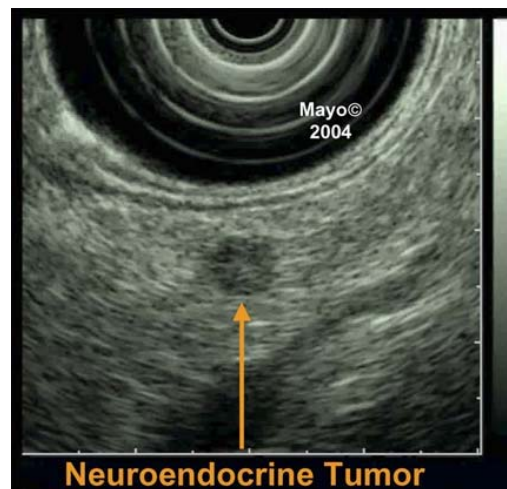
Neuroendocrine pancreatic tumor. One of many small nonfunctioning neuroendocrine tumors identified by endoscopic ultrasound in a patient with multiple endocrine neoplasia (MEN) I syndrome. CT and somatostatin receptor scintigraphy failed to identify any of the lesions.
